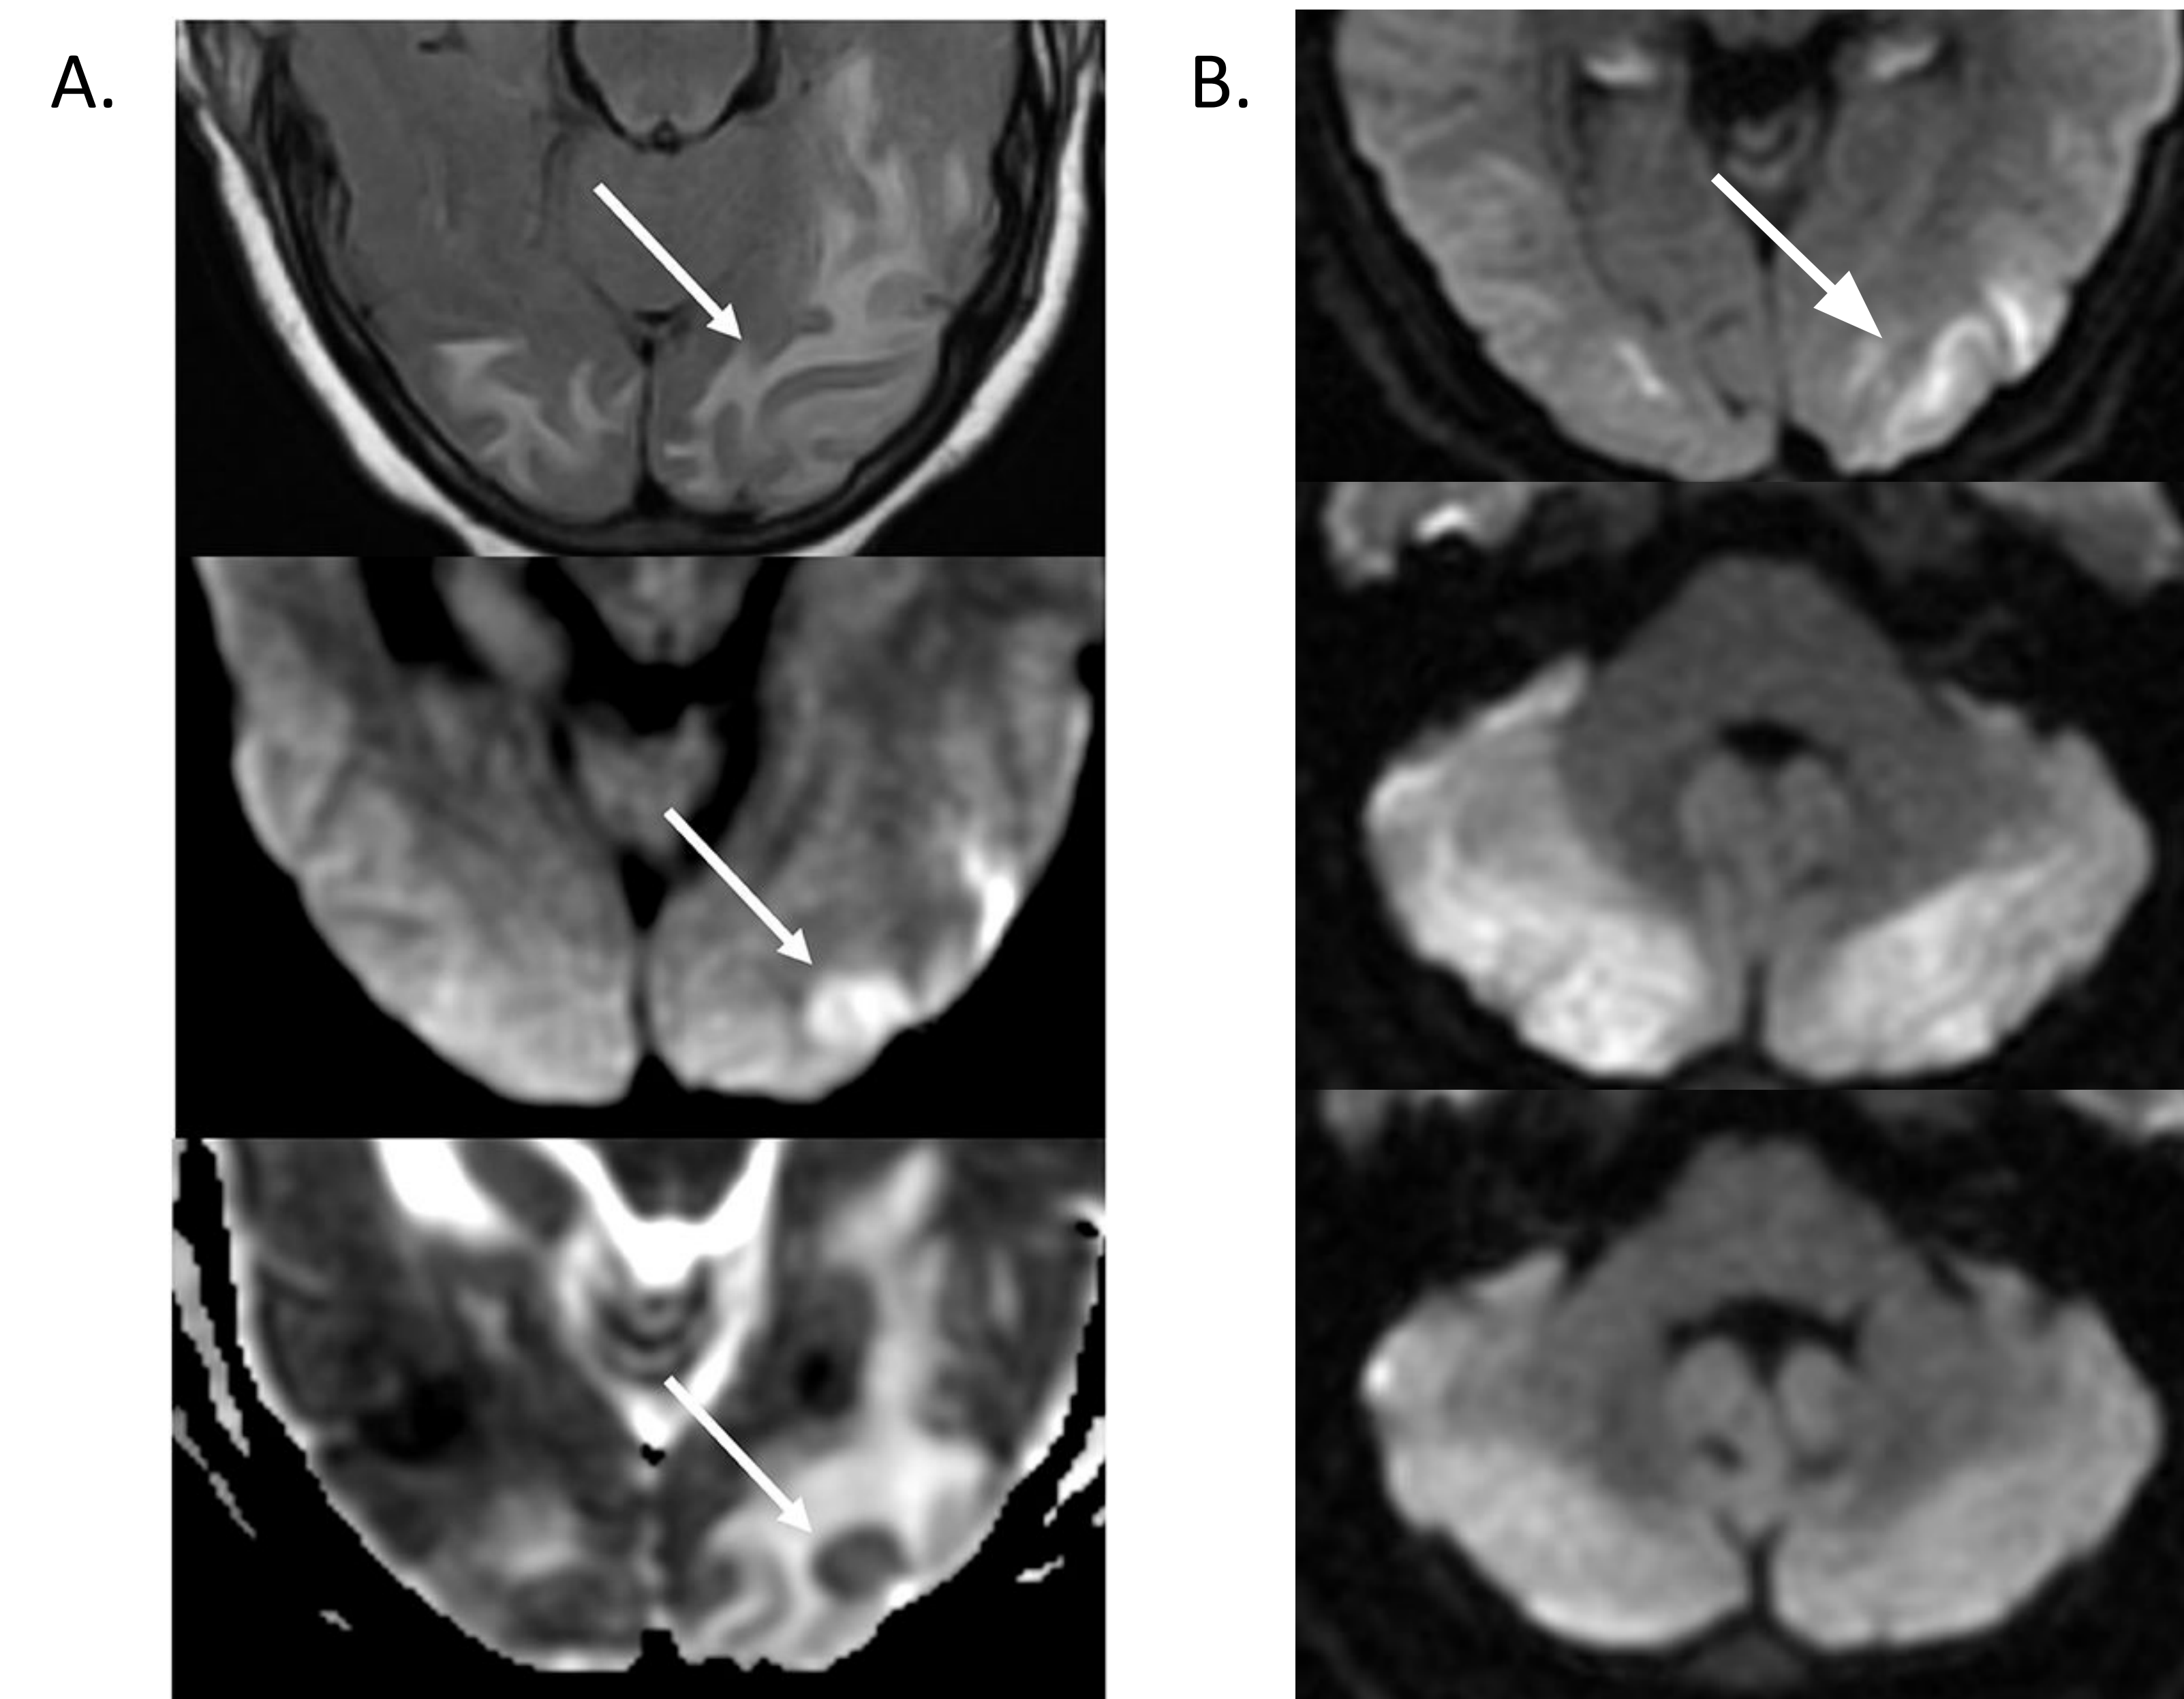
MRI T2 Flair, DWI, and ADC map example of uncontrolled hypertension showing bilateral posterior and occipital lobe edema consistent for PRES⁶.
